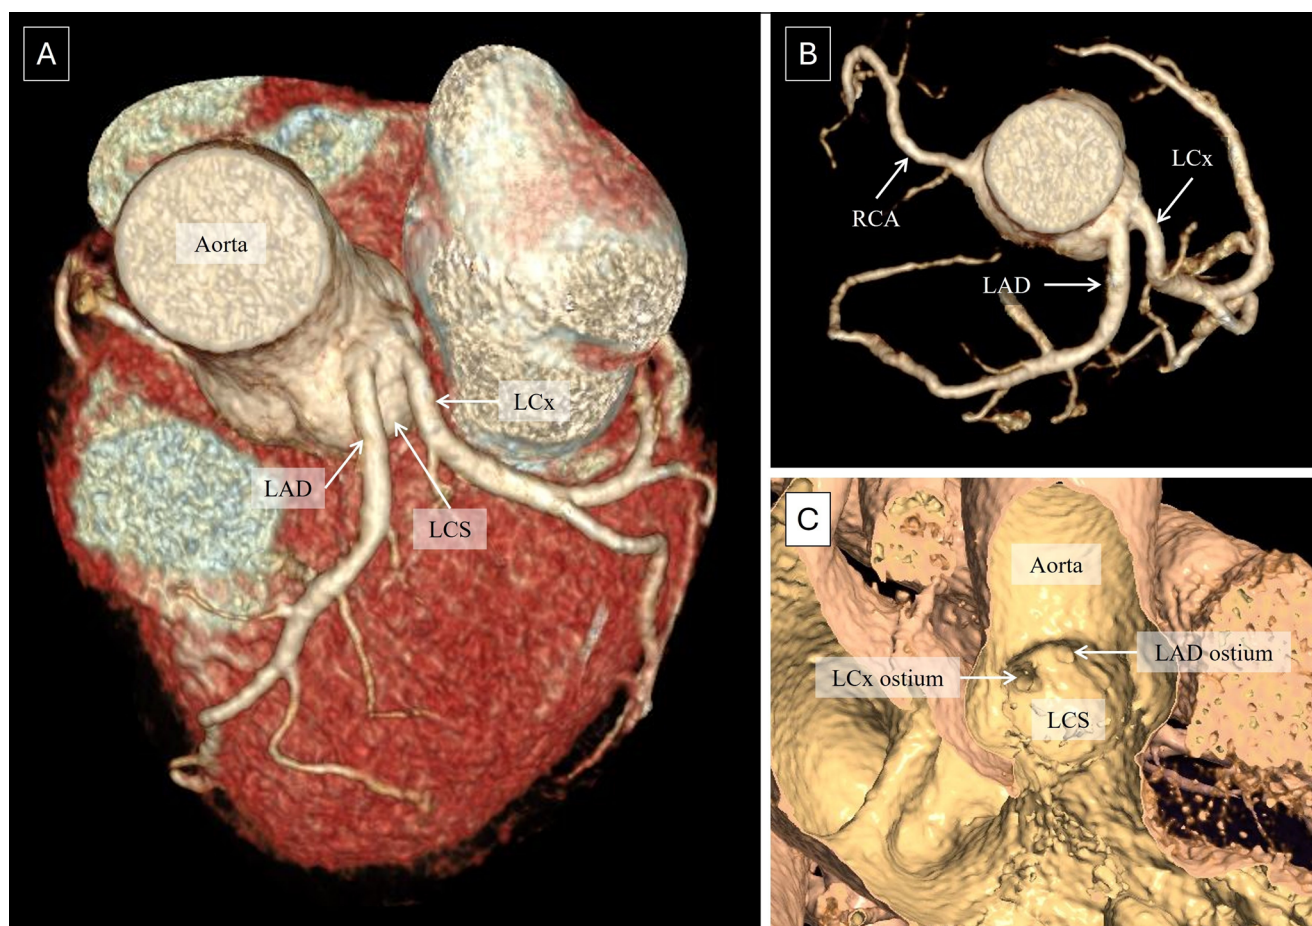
(A, B) Volume-rendered images of coronary computed tomography angiography demonstrate absence of the left main coronary artery segment. The left anterior descending (LAD) artery and the left circumflex (LCx) artery are seen arising directly from the left coronary sinus (LCS) with separate ostia. The right coronary artery (RCA) is seen orthotopically arising from the right coronary sinus. Virtual dissection image (C) shows the separate ostia of the left anterior descending (LAD) and left circumflex (LCx) arteries.
